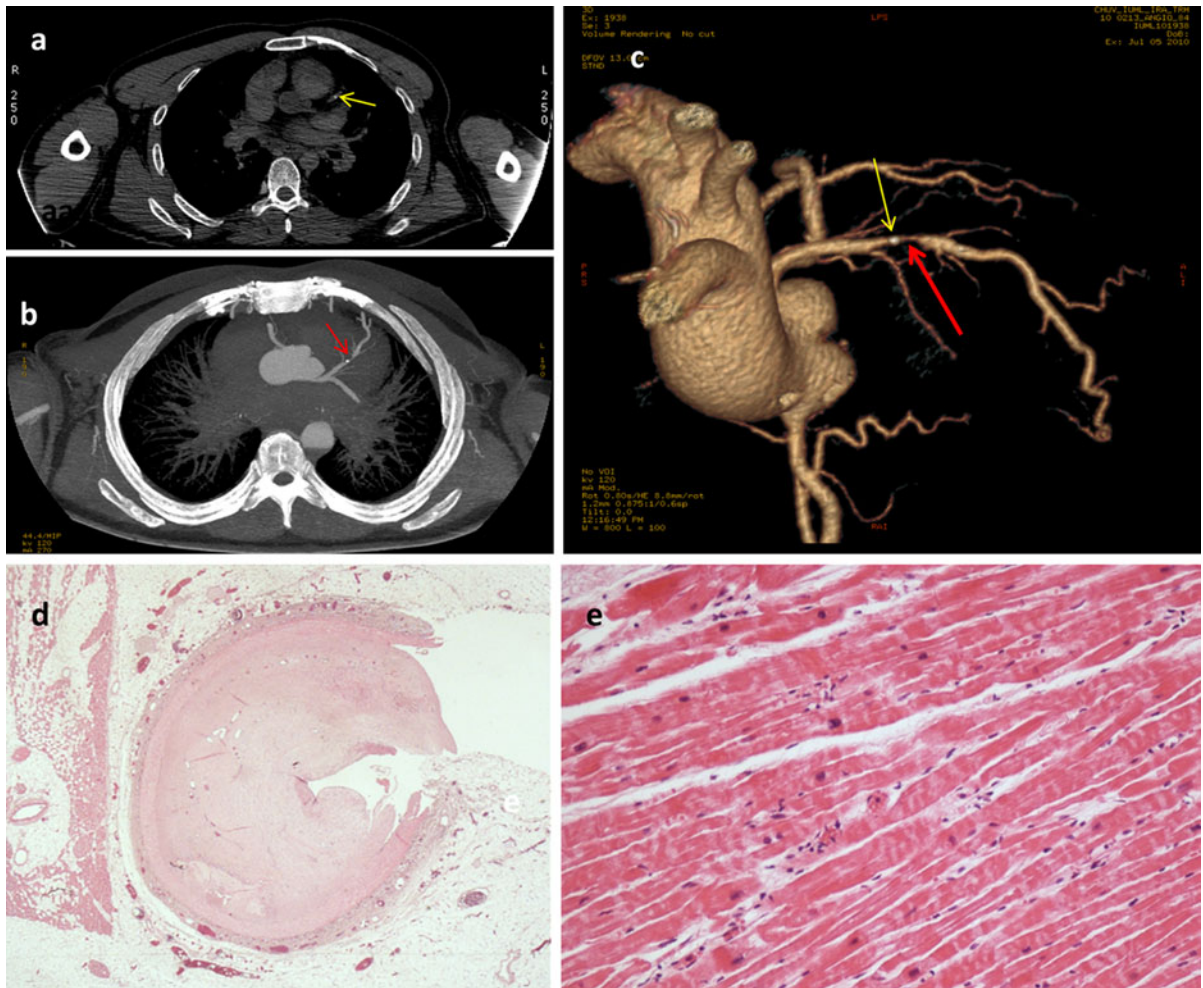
Case of a 45 year old man who died suddenly while jogging (case no 17): native CT image (a) shows an isolated calcification of the middle part of the LAD artery (arrow). Angio-CT (b) shows a partial occlusion (arrow) of the LAD, immediately distal to the calcification. A 3D-reconstruction performed on the data of the arterial phase of PMPCTA
